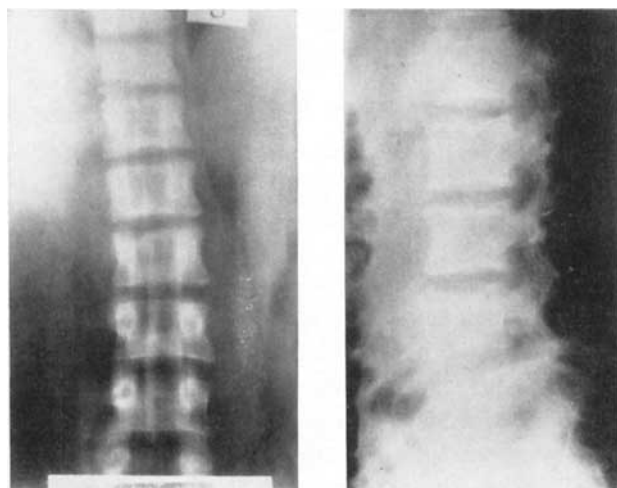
Incipient tuberculous spondylitis. The lateral roentgenogram shows indistinct erosion of the discal surfaces. Tomography indicates the site of the lesion and its extent.
